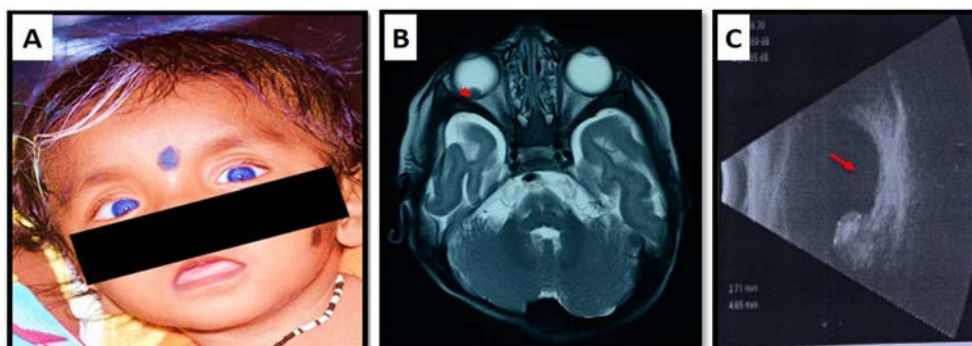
Retinoblastoma patient with Waardenburg syndrome A. Clinical picture showing heterochromia iridis, telecanthus, high arch palate, low set ears and white forelock. B. MRI examination showing calcification in right eye in vitreous chamber pointed by arrow. C. USB- Scan showing mass in the inferior retina of right eye with hyperechoic internal structure shows calcification with no orbital extension, confirming retinoblastoma
